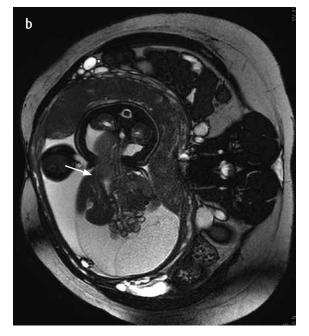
MRI a) with coronal T2 information; b) with axial T2 information. Patient 31.2 weeks gestation, with a midline wall defect at the level of the umbilicus, which protrudes the contents of solid viscera and intestinal loops (arrow), which are contained in a low signal membrane with ascites, which generates a marked decrease of the abdominal circumference.
